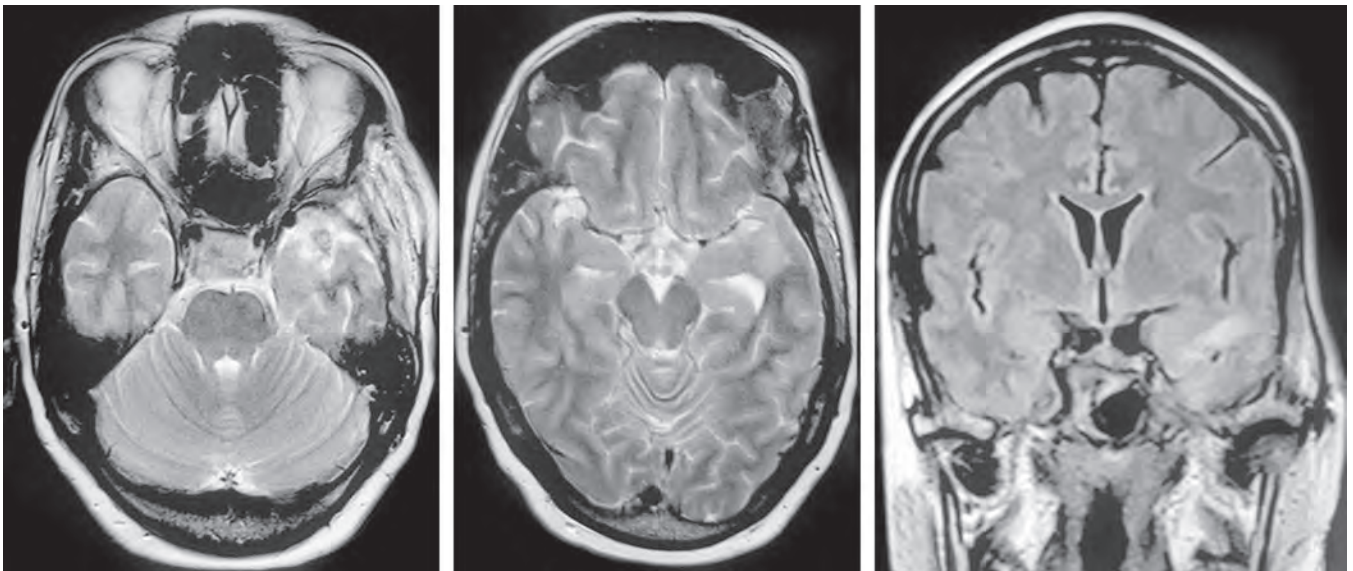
Post-operative contrast MRI of the brain showing total excision of the intracranial lesion
